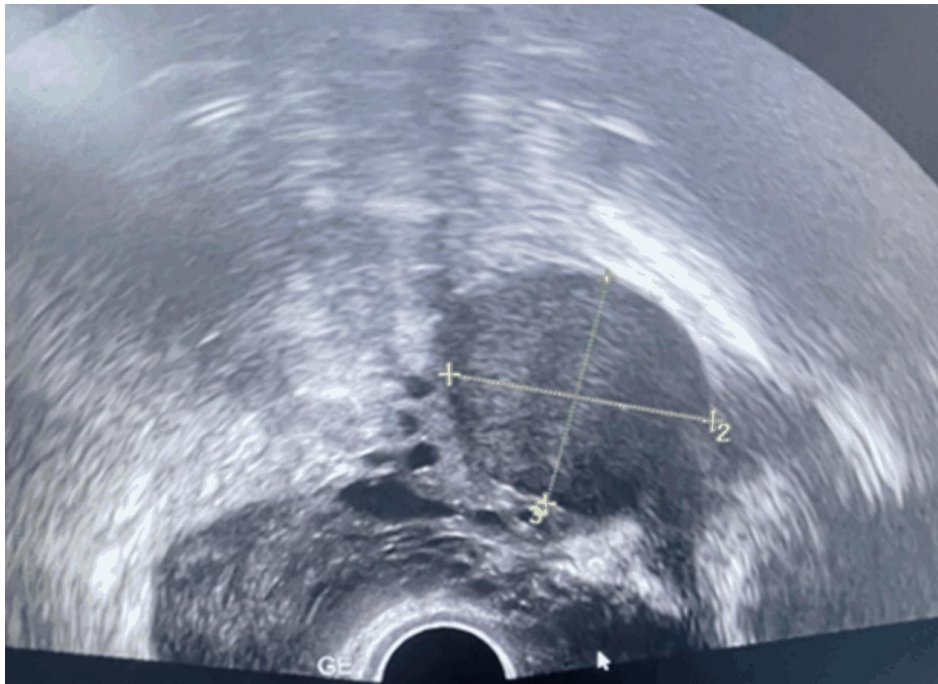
Transvaginal ultrasound image showing an avascular ground-glass right ovarian cystic lesion, compatible with ovarian endometrioma
